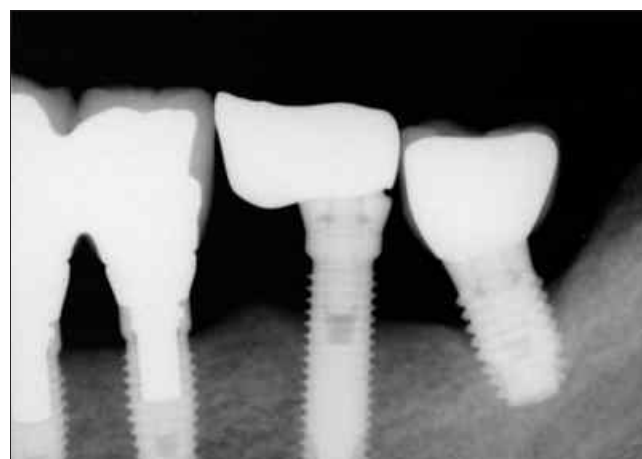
Periapical radiograph 1 year after prosthetic loading. Approximately 2.4 mm of crestal bone loss is shown.
